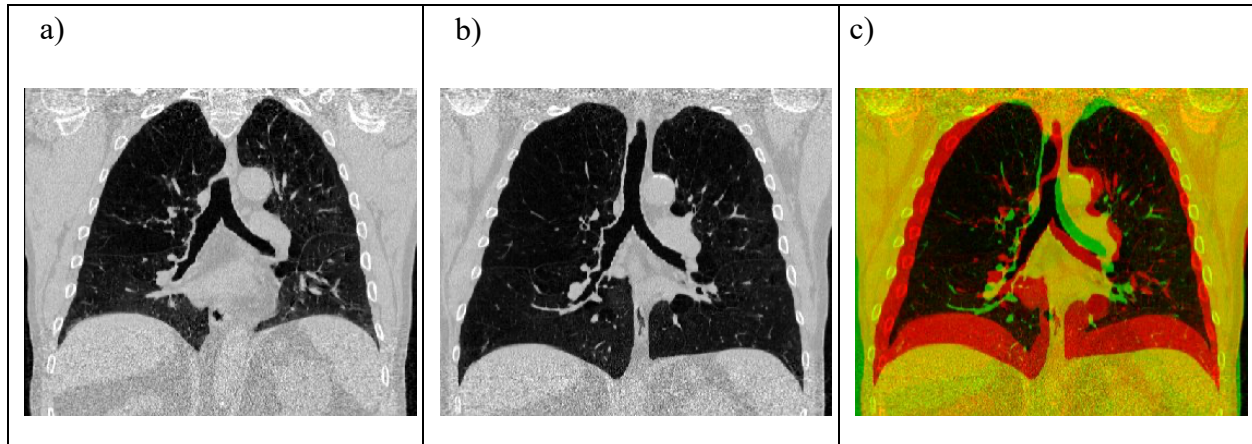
Example CT slices for a patient 5 showing a) RV (5.11 Liters), b) TLC (7.80 Liters) geometry, and c) an overlaid image where red and green represent RV and TLC, respectively
